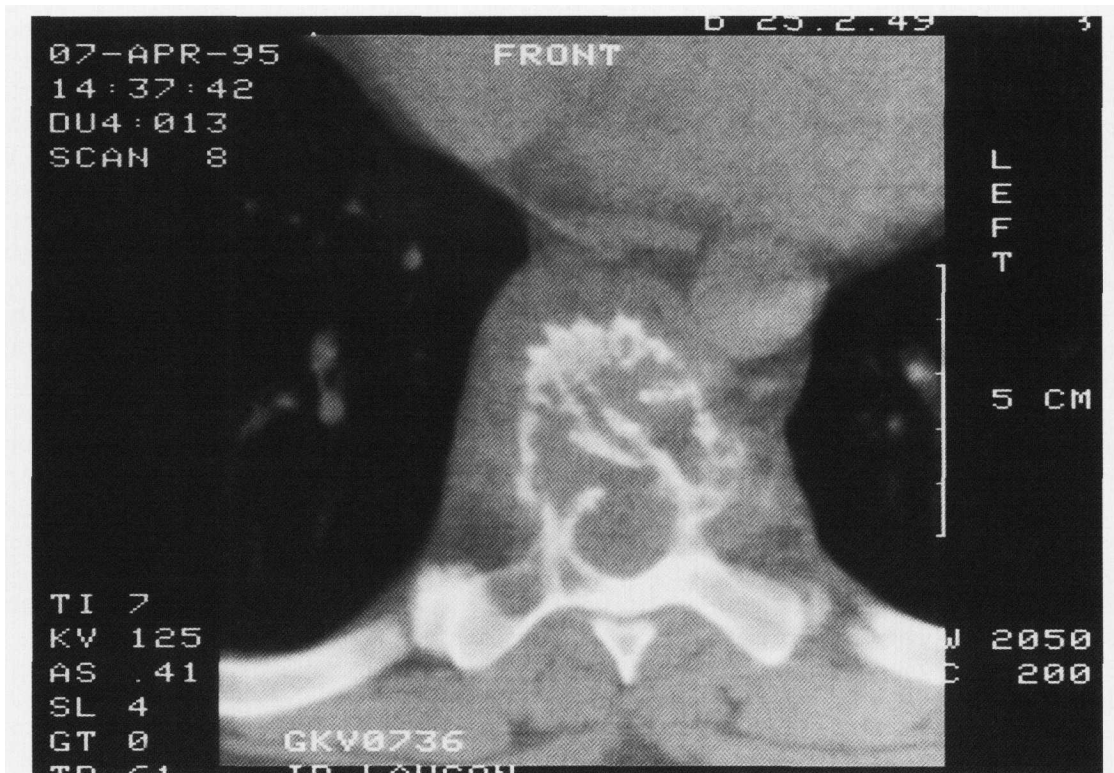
CT shows destruction of T8 without any evidence of lymph node enlargement
